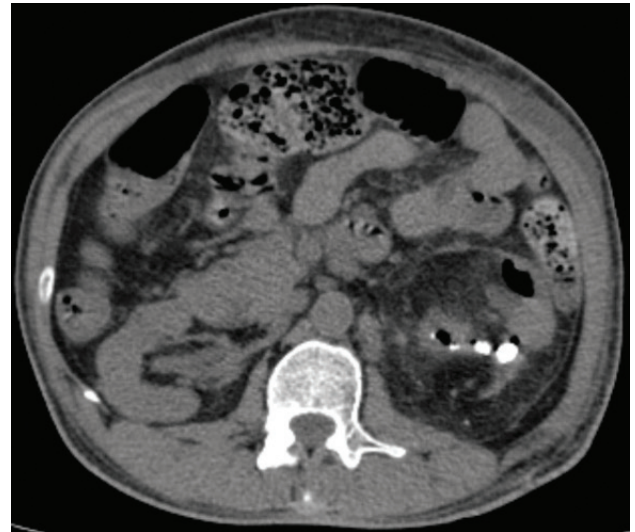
Axial non contrast CT through the level of bilateral kidneys.
